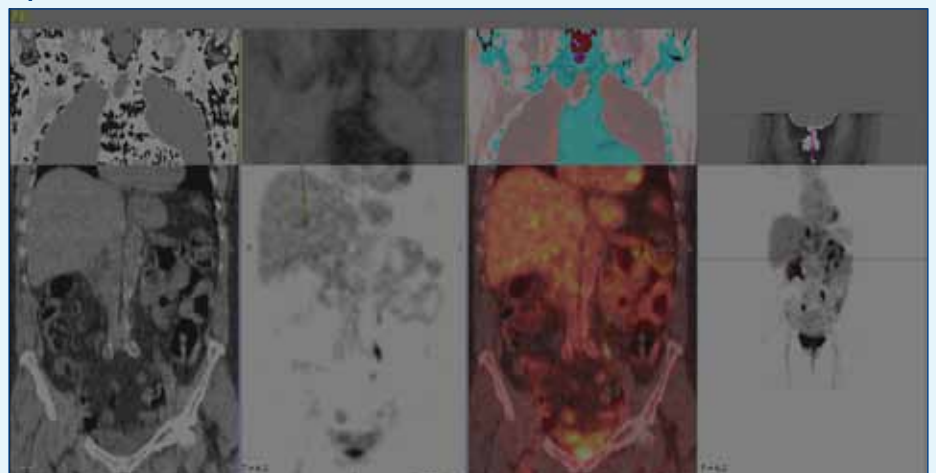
Positron emission tomography computed tomography in a patient with colorectal cancer shows a single lesion in the liver, with increased fluorine-18-deoxyglucose uptake, consistent with metastatic deposit.
